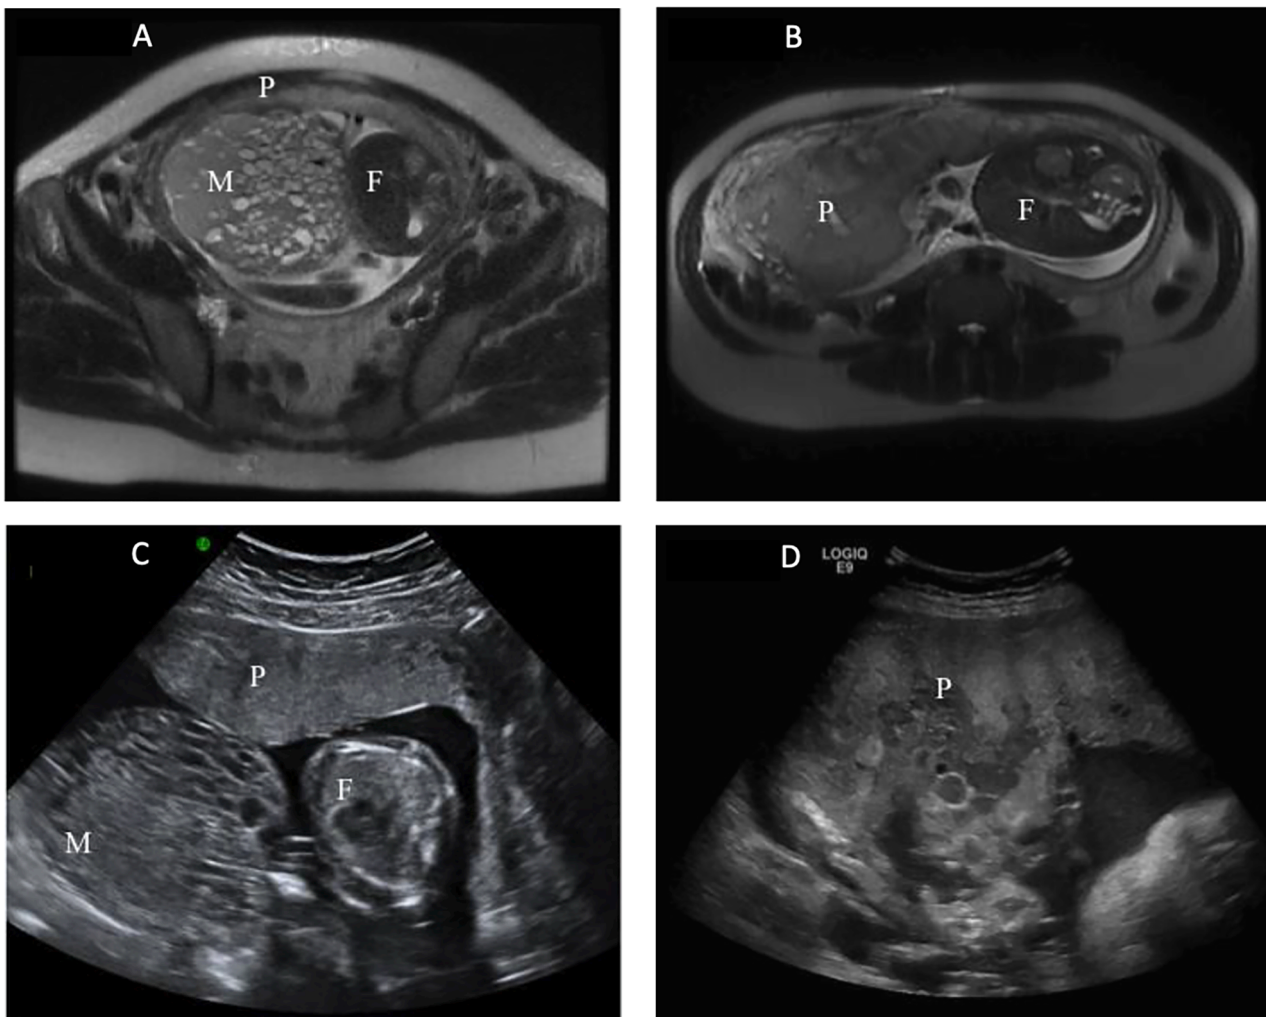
A. Axial T2 weighted MRI of the abdomen and pelvis demonstrating twin molar pregnancy. Normal placenta (P), Molar pregnancy (M), and Fetus (F). B: Axial T2 weighted MRI of the abdomen and pelvis demonstrating PMD. There is no clear plane separating the cystic component and normal placenta. Placenta (P), Fetus (F). C: Transverse abdominal ultrasound demonstrating twin molar pregnancy. Normal placenta (P), Molar pregnancy (M), and Fetus (F). D: Transverse abdominal ultrasound demonstrating PMD. Again no clear plane is seen between the cystic component and normal placenta. Placenta (P).
